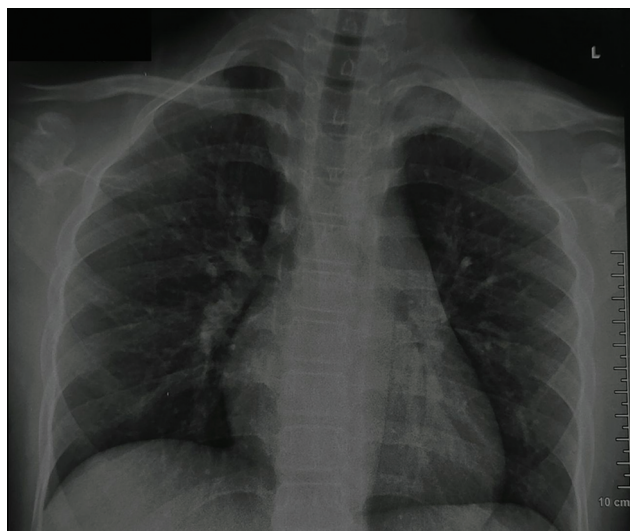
Introductory radiograph. Frontal chest radiograph demonstrates exuberant hyperostosis and solid periosteal reaction with the medial and middle thirds of the left clavicle. Right clavicle and bony rib cage appear normal.
